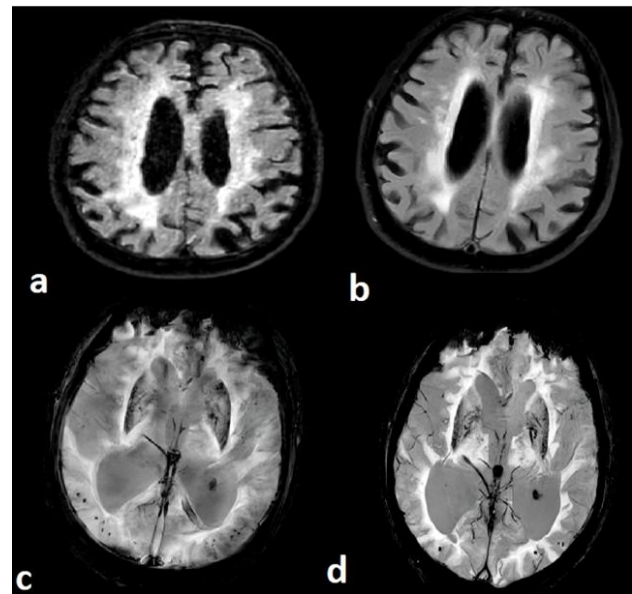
Comparison of pre- and post-treatment magnetic resonance imaging images: Periventricular hyperintensities extending to the subcortical white matter on T2-weighted FLAIR imaging (before pulse methylprednisolone) (a), periventricular hyperintensities on T2-weighted FLAIR imaging (after pulse methylprednisolone) (b), bilaterally microbleeding on the posterior parietal region of the cerebral cortex on SWI sequential imaging before treatment (c), & reduced microbleeding on the posterior parietal region of the cerebral cortex on SWI sequential imaging after treatment (d) (Department of Radiology, Balikesir University Hospital [patient data anonymized])
